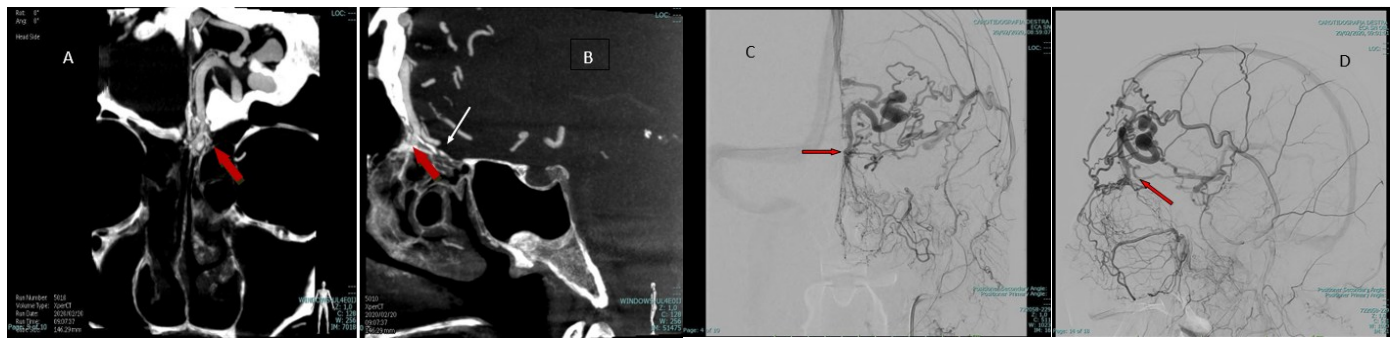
Patient 1: CT (A) sagittal slice; (B) coronal slice; DSA, arterial phase left ECA, (c) postero-anterior view Figure 1. (D) lateral view; Arterio-venous fistula of the anterior cranial fossa fed by the anterior meningeal arteries and branches of the Sphenopalatines and Infraorbital arteries drained towards the nasal cavity through the foramen caecum. Red arrows show enlarged VFC; white arrow shows Ethmoidal plane.
